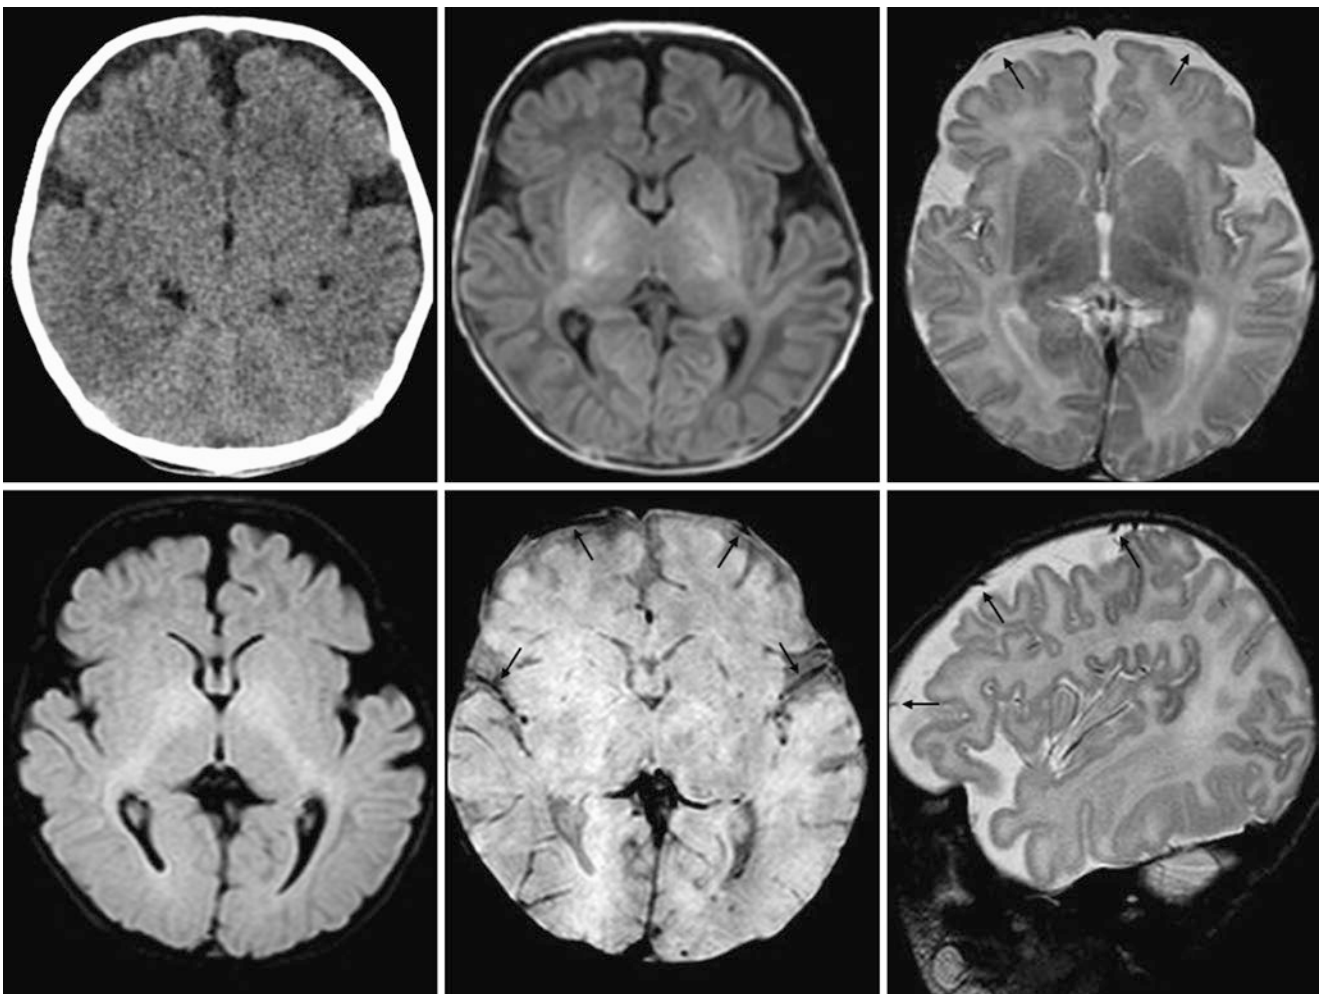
An 8-week-old with “irritability” had BESSI on an NECT (*top left*), with enlarged SASs within the sylvian fissures and along the frontal convexities. An otherwise negative 1.5T MRI included axial T1WI (*top middle*), T2WI (*top right*), FLAIR (*bottom left*), SWI (*bottom middle*), and sagittal T2WI (*bottom right*). Note cortical veins (*thin arrows*) traversing the SASs. Follow-up imaging was not obtained. The patient’s subsequent development was normal
